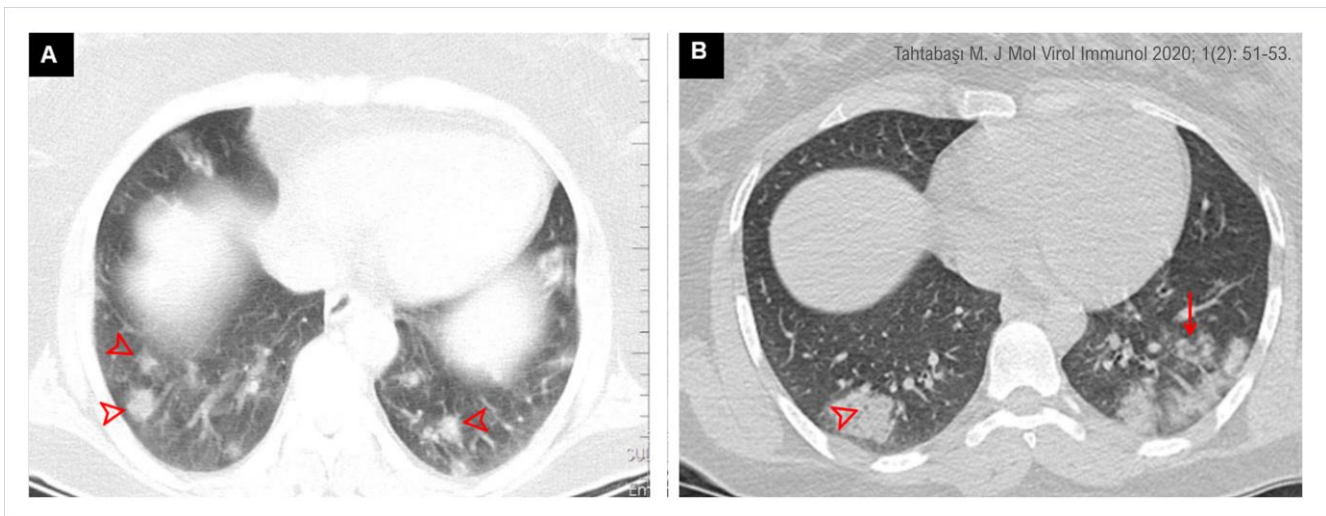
Chest CT images of two different patients with positive rRT-PCR test in the lung window. A) CT images show multiple ground glass opacities (*arrowheads*) located in the lower lung lobes and periphery of both lungs. B) CT images of a different patient show ground glass opacities and patchy consolidations (*arrow*) in the lower lobes and periphery of the lung. Pay attention to the air bubble sign (*arrowhead*) within the lesion.
